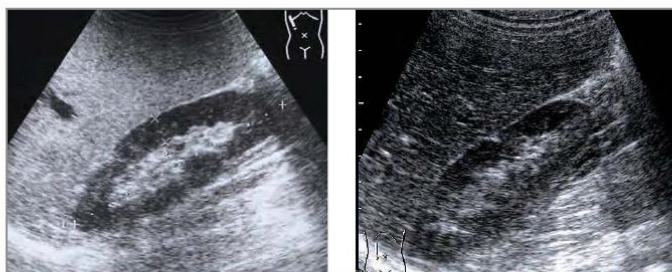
c Ultrasound: Fatty liver
